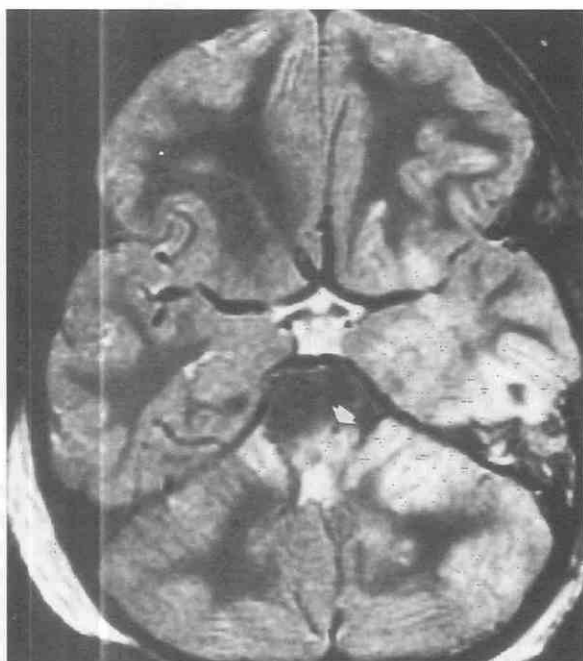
Axial T2-weighted (2500/80) MR image shows areas of diffuse axonal injury in the pons, middle cerebellar peduncles, and left-cerebellar hemisphere. The pontine lesion contains a focus of acute hemorrhage (*small arrow*). Hemorrhagic contusion is present in the left temporal lobe.
